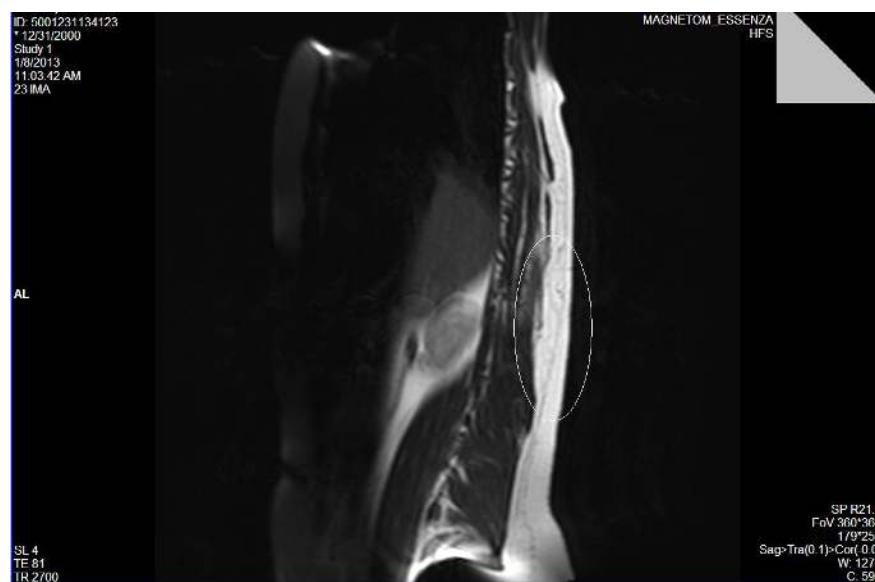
MRI appearance , longitudinal section that shows cranio-caudal size of the hemangioma (marked in circle)
